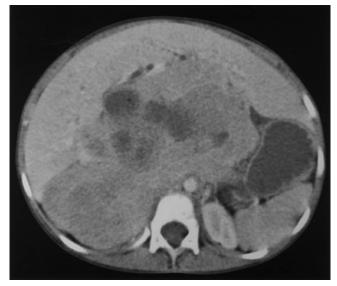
CT image of enormous abdominal mass in 5 y old with stage 4 neuroblastoma. Tumor shrank with chemotherapy and was successfully resected. Patient is in complete remission 16+ mo later.
